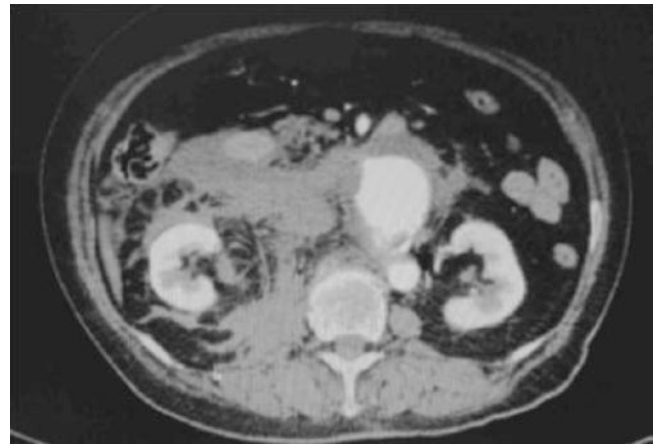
Preoperative abdominal CT
